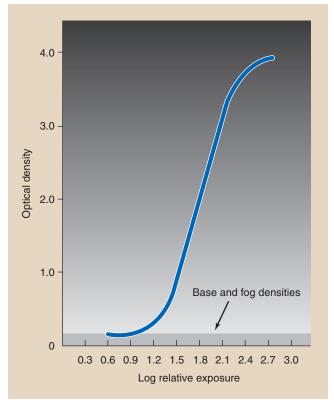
Base and fog densities reduce radiographic image contrast and should be as low as possible.
